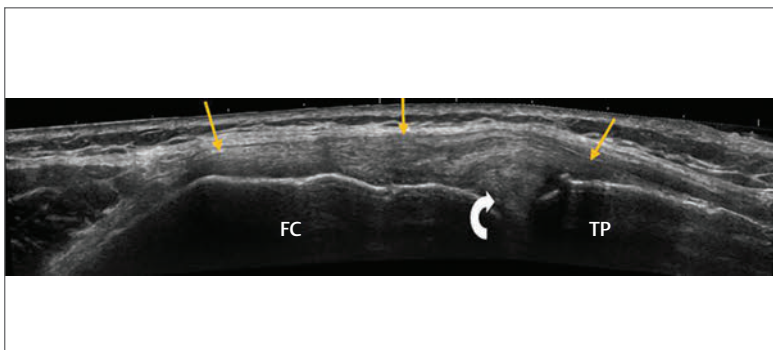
Longitudinal image of the medial aspect of the knee. The medial collateral ligament (yellow arrows) can be seen to run superficially over the joint from the medial femoral condyle (FC) to the medial tibial plateau (TP). The medial meniscus (white curved arrow) can be seen as an echogenic triangle below the medial collateral ligament. Although the meniscus can be seen with ultrasound and many peripheral tears may be identified, subtle tears and tears located more centrally cannot be seen.
